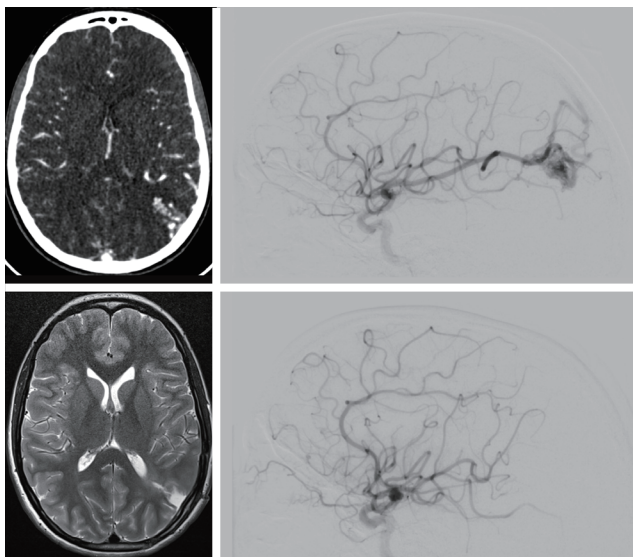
Migrainous headache and unruptured brain arteriovenous malformation (bAVM). A 13-year-old girl presented to her paediatrician with intractable migraine headache, always on the left side of the head. computed tomography angiography and angiogram (pre-operative) demonstrated a left parieto-occipital bAVM, unruptured. Due to the symptoms the child and her family elected for craniotomy and resection, which achieved cure (post-operative). Her headaches resolved completely, and she is now studying nursing.
